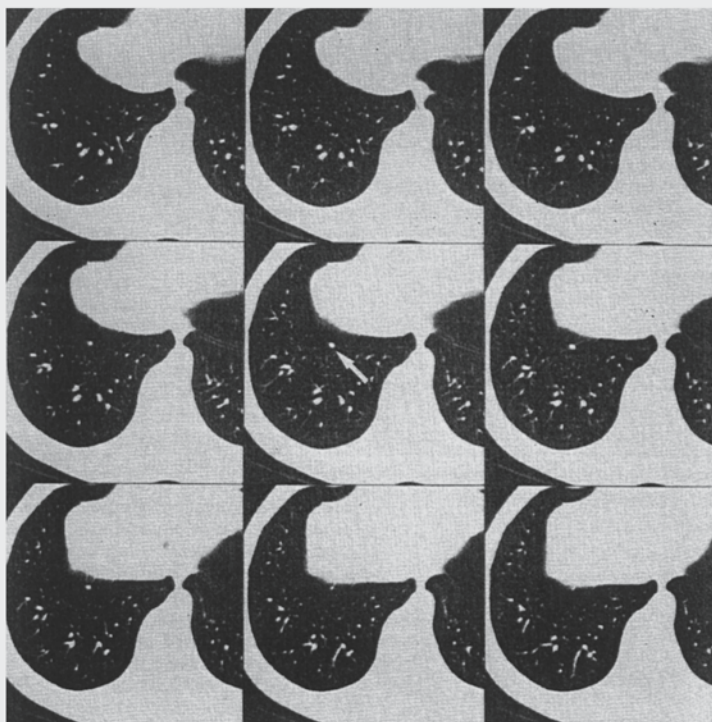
Spiral volumetric CT study of a pulmonary nodule (arrow) (12 1-second scans of a 24-mm subvolume, 2-mm nominal section thickness, 2 mm/sec table feed). Nine consecutive reconstructions, spaced 1 mm apart, are shown.
